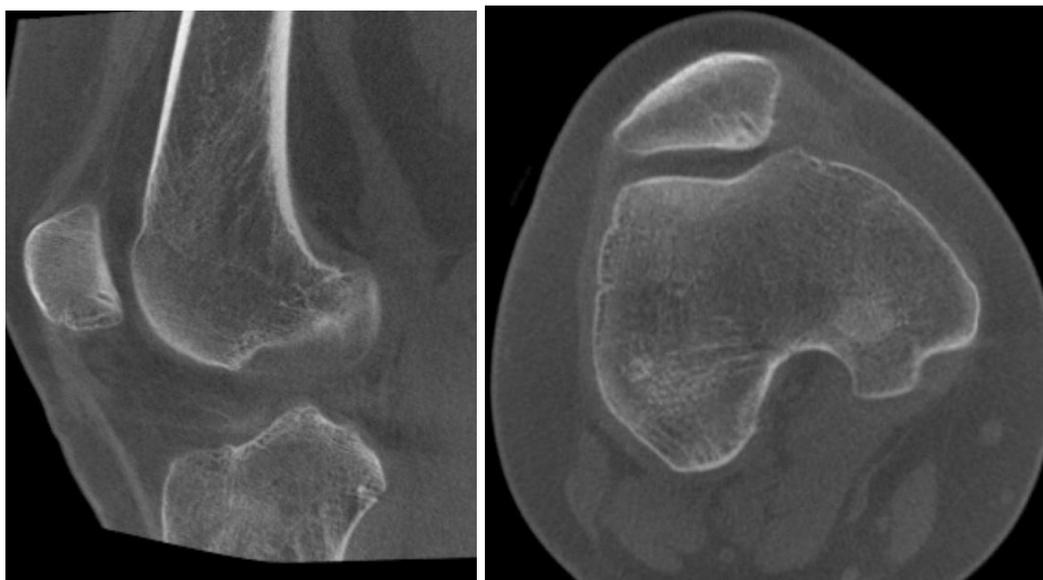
CT images, taken 13 months after operation, showed smooth and intact joint surface.
